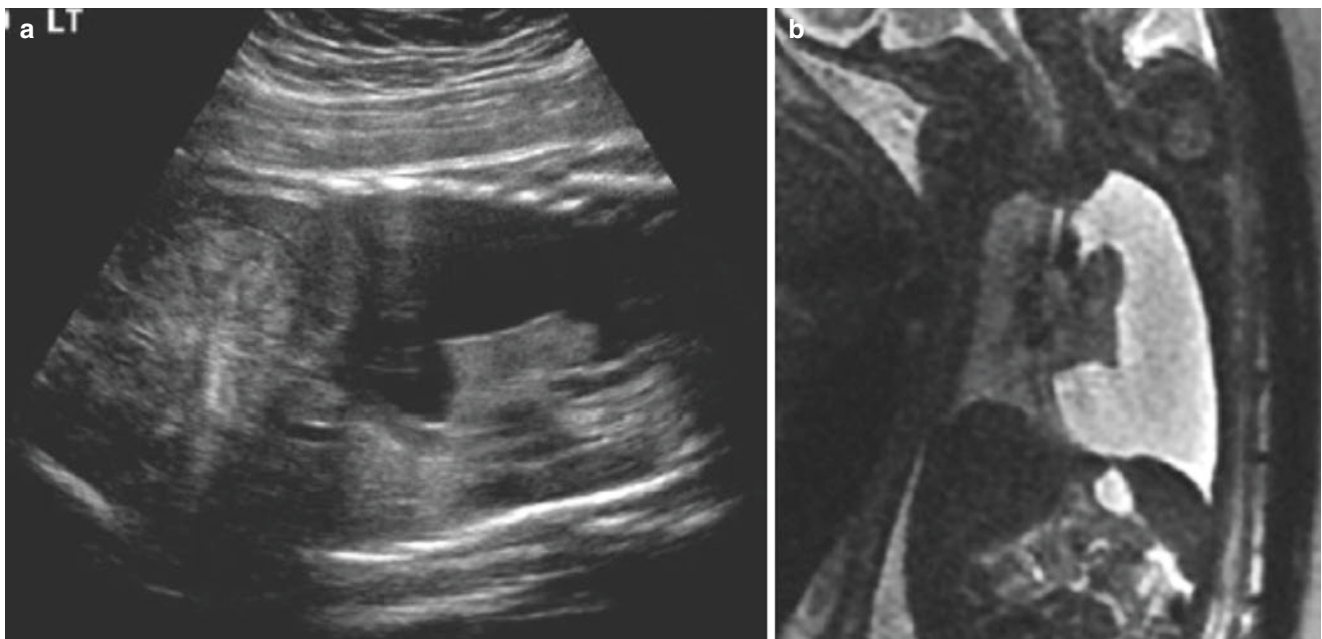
Chylous effusion. (a) Coronal US of the chest demonstrates a large fluid collection in the left hemithorax compressing the left lung. (b) SSFSE coronal MR image confirms the presence of a large left pleural effusion with compressed lung parenchyma and no underlying lung mass
